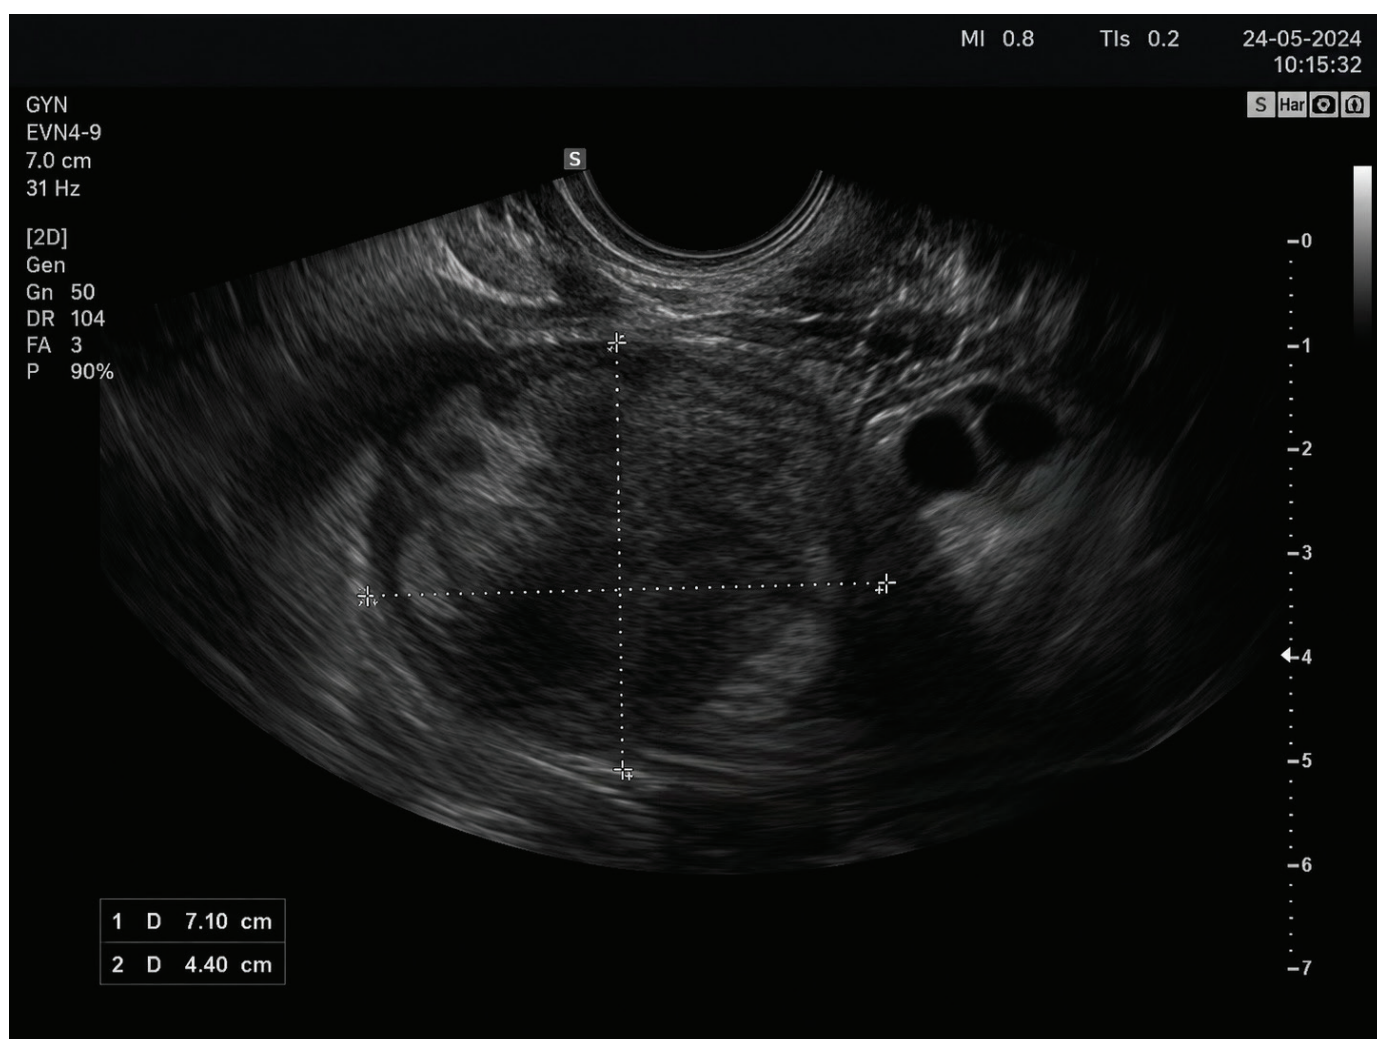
Figure | Ultrasound examination: Right ovary with suspected intraligamentary fibroid measuring 71×44 mm.
